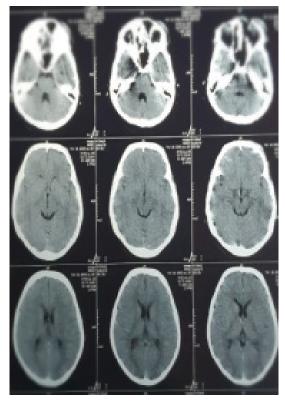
Normal CT scan of head injury patient.
